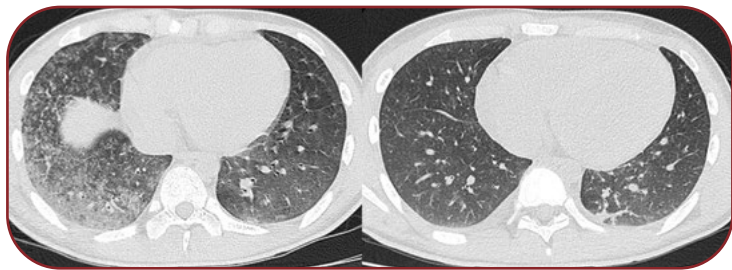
Chest computed tomography scan performed at the time of admission showed diffuse ground-glass opacities in both lungs with peripheral distribution.
